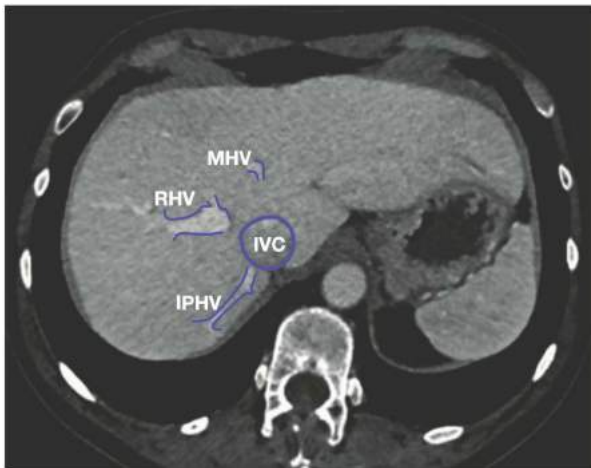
• Axial CT showing an accessory hepatic vein. The inferior posterior right hepatic vein (*IPHV*) occurs in up to 25% of patients. Notice the position of the *IPHV*, far posterior on the liver. This is of utmost importance to characterize prior to operating on the liver. Also seen are the right hepatic vein (*RHV*), *MHV*, and the *IVC*.
